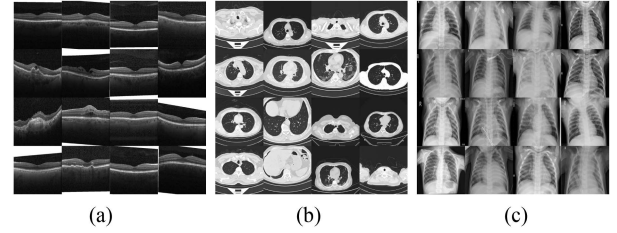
Some randomly selected samples of retinal OCT, lung CT, and chest X-ray datasets. (a) Retinal OCT. (b) Lung CT. (c) Chest X-ray.
